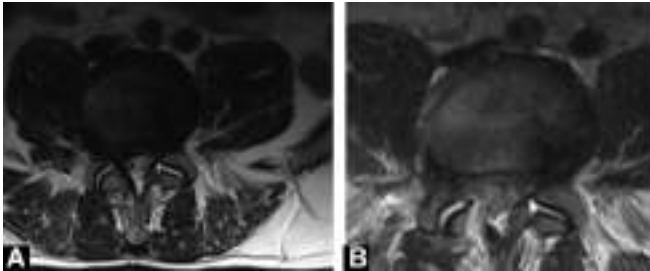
Preoperative (A) and postoperative (B) axial MR images of a case with extraforaminal disc herniation that underwent microdiscectomy using extraforaminal approach
